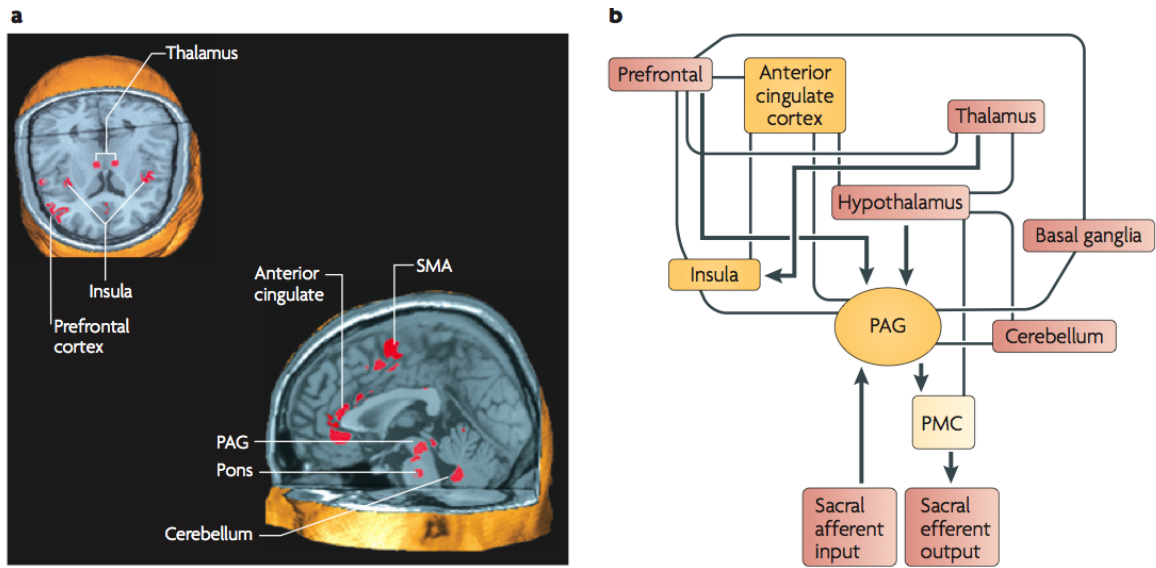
Brain areas involved in the regulation of urine storage. a | A meta-analysis of positron-emission tomography and functional MRI studies that investigated which brain areas are involved in the regulation of micturition reveals that the thalamus, the insula, the prefrontal cortex, the anterior cingulate, the periaqueductal grey (PAG), the pons, the medulla and the supplementary motor area (SMA) are activated during the urinary storage. b | A preliminary conceptual framework, based on functional brain-imaging studies, suggesting a scheme for the connections between various forebrain and brainstem structures that are involved in the control of the bladder and the sphincter in humans. Arrows show probable directions of connectivity but do not preclude connections in the opposite direction. Part a reproduced, with permission, from REF. 64 © (2007) Blackwell Science. Part b modified, with permission, from REF. 63 © (2005) Wiley-Liss.
